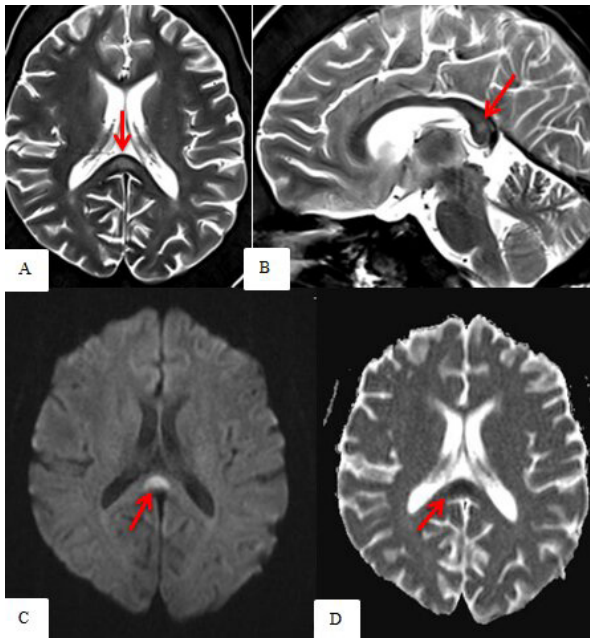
MRI showing CLCC; A) axial T2w and B) sagittal T2w images showing hyperintense lesion at the splenium of the corpus callosum (A,B; red arrows). C) DWI and D) ADC map show restricted diffusion of the lesion (C,D; red arrows)
